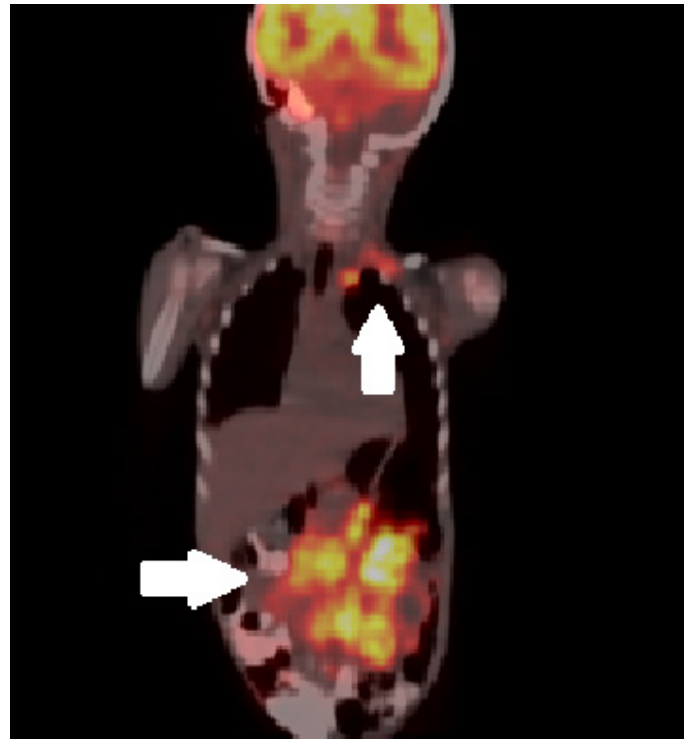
PET-CT images showing multiple intense hypermetabolic cervical and abdominal lymphadenopathies.
